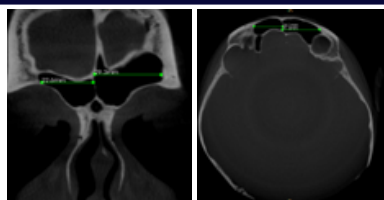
Figure (c) and (d): CBCT images showing measurement of transverse dimensions of frontal sinus from coronal (c) and axial
